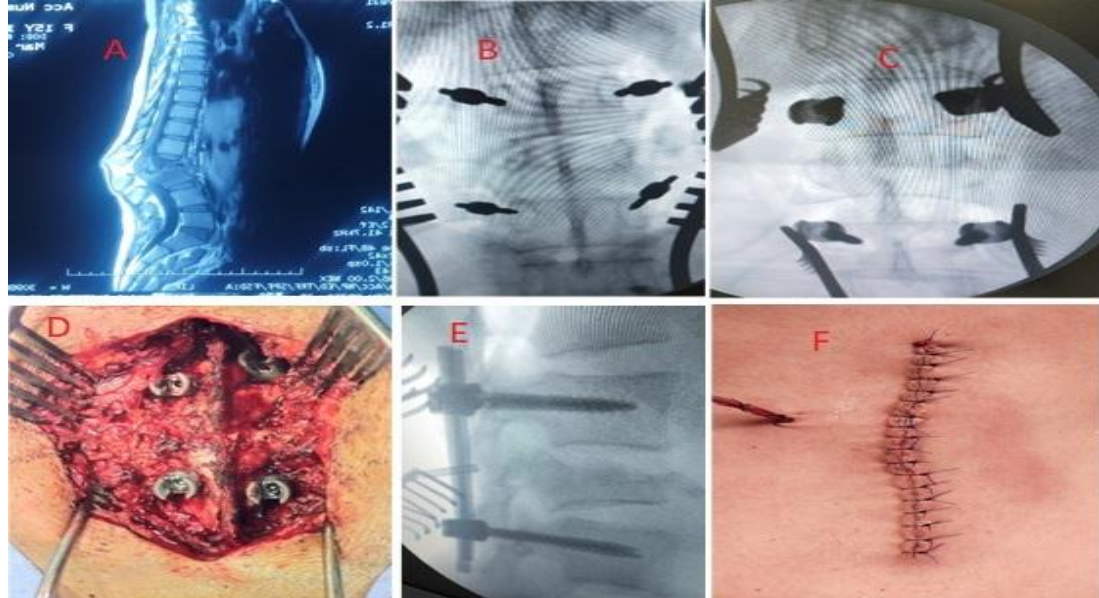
Image A shows MRI of fractured vertebra B Steinmann pin inserted into the pedicle C shows anteroposterior view of the screw that are placed into the body D real image of the screw E lateral view of rods and screws F shows image of skin after closure.
